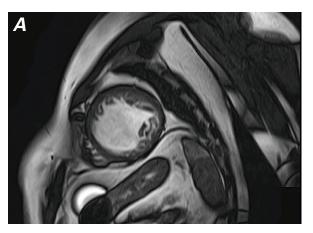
At presentation, a cardiac magnetic resonance image (short-axis, mid-cavity view) at end-diastole reveals the markedly dilated left ventricle (LV).
